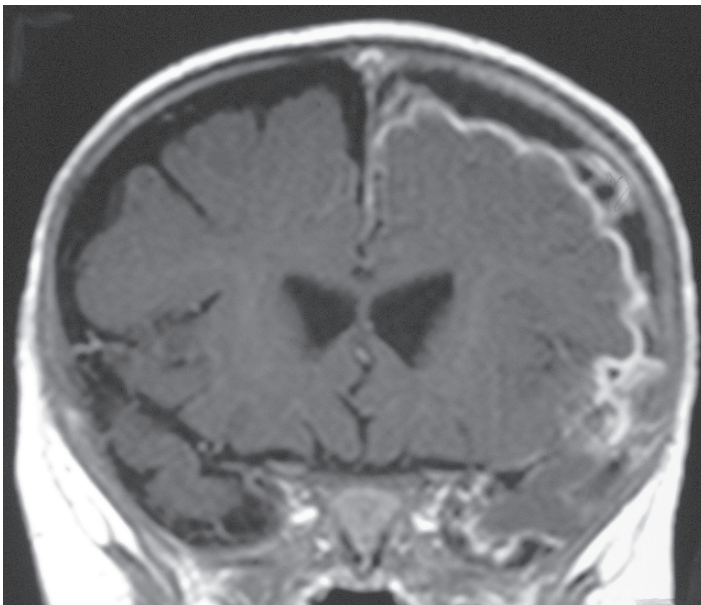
Left subdural empyema. The coronal gadolinium-enhanced T1-weighted MRI scan shows an extracerebral fluid collection, slightly more intense than CSF. There is contrast enhancement of the meninges and cortical surface, and within the subdural space as well. The patient was an 11-month-old boy with pneumococcal meningitis. (Image courtesy of J. Robert Kirkwood, M.D.)
